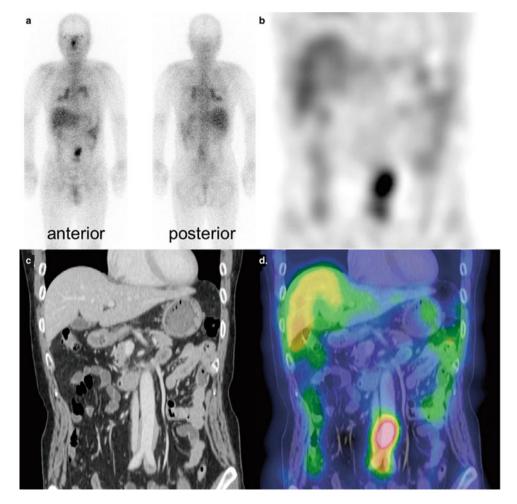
Detection of pancreatic, pulmonary, and periaortic lesions by whole-body ⁶⁷Ga scintigraphy (a) and SPECT (b-d)
